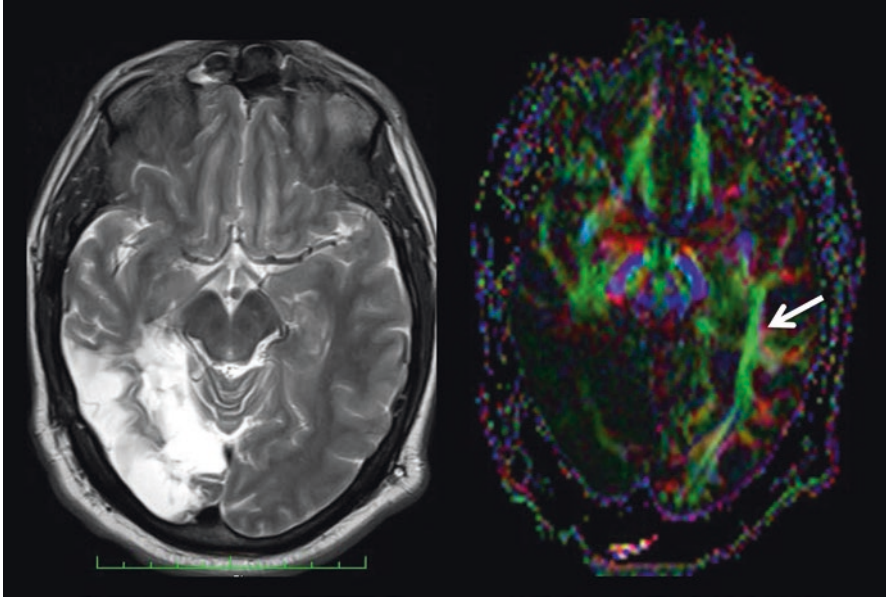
(Left) Axial T2 MRI post-resection for an astrocytoma involving much of the right posterior temporal-occipital region. (Right) DTI at a similar axial section demonstrates the absence of any viable white matter connections of the right hemisphere. The arrow points to an intact occipitotemporal fasciculus. Scans in a radiological perspective, with left on the viewer's right
